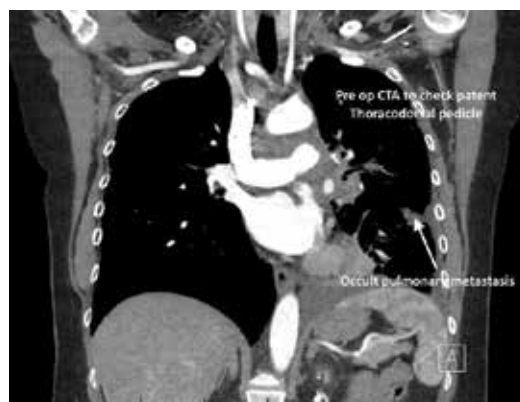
CTA showing occult pulmonary metastasis.
